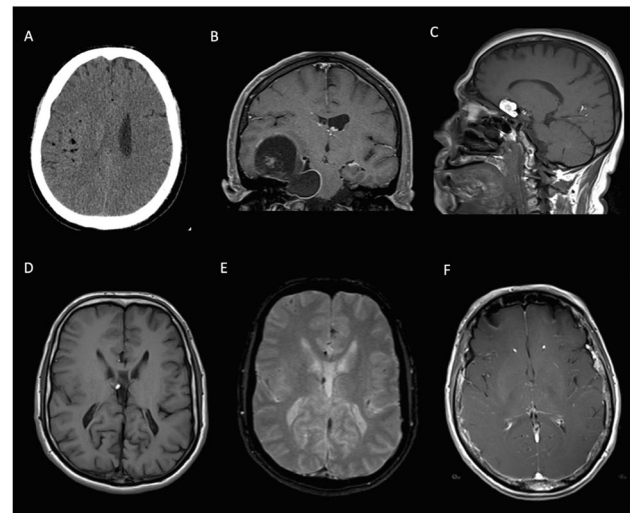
Characteristic imaging features of ruptured intracranial dermoid cysts. Head CT (axial) (A) showing hypoattenuating fat droplets in the subarachnoid space along frontal and parietal sulci, after head trauma, in a patient with a dermoid cyst located in the right anterior temporal region. Brain MRI. (B) T1 (SE) post-gadolinium (coronal view) - slight peripheral enhancement of the lesion's capsule after rupture of a dermoid cyst, in the same patient as figure A. (C) Dermoid cyst at the right lateral aspect of the *planum sphenoidale* showing hyperintense signal on sagittal T1 (SE) weighted imaging and fat droplets within the subarachnoid space, along the parieto-occipital sulcus, in a patient presenting with headache. (D) Fat droplets within the III ventricle on axial T1 SE with blooming artifacts (E) in axial T2 gradient echo sequence, in a patient with an incidental right frontal-basal dermoid cyst. (F) Leptomeningeal enhancement in axial T1 SE post-gadolinium due to chemical meningitis, as complication of dermoid cyst rupture, in another patient presenting with headache.
